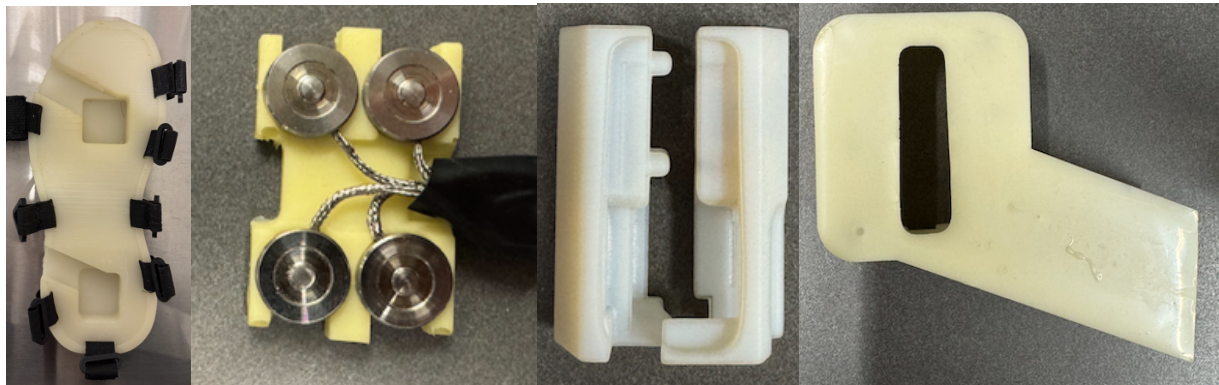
Ultrashoe components. The molded Ultrashoe sole (left), Honeywell Model 13 subminiature load cells on their molded housing (middle left), the 3D printed probe holder (middle right), and the heel housing that holds the components and fits into the Ultrashoe cavity. Not pictured: forefoot housing and ultrasound probe.
